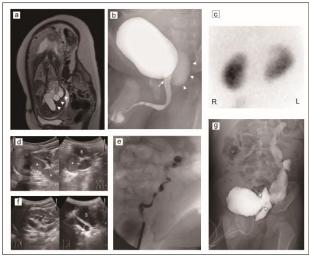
(a) Prenatal magnetic resonance imaging showed a left megaureter (arrowheads). (b) Voiding cystourethrography (VCUG) showed left grade I reflux (arrowheads), suggesting that the contrast medium flowed up from the posterior urethra (arrow). (c) Dimercaptosuccinic acid renal scintigraphy demonstrated left duplex system with decreased uptake in the upper moiety. (d) Large amounts of debris (*) persisted in the left dilated upper ureter on ultrasonography. B: bladder. (e) Retrograde pyelography through the left ureteral orifice in the bladder showed a left non-dilating lower pole ureter. (f) Dilation of the left upper ureter improved on ultrasonography after the side-to-side ureteroneocystotomy. B: bladder. (g) VCUG revealed a massive reflux into the left upper pole ureter through the anastomosis (arrowheads)
